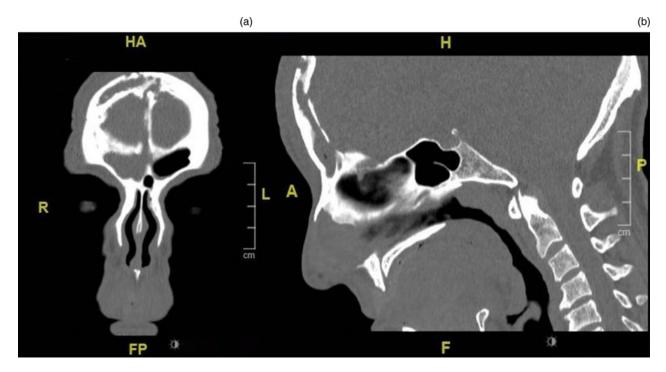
(a) Coronal and (b) sagittal computed tomography scans of the paranasal sinus, showing extensive chronic infective changes originating in the right frontal sinus, with destruction of the inner and outer tables of the vault, and associated soft tissue swelling in the frontal scalp tissues. Appearances are reminiscent of Pott's puffy tumour, but in a more chronic state. HA = head/anterior; H = head; R = right; L = left; A = anterior; P = posterior; FP = feet/posterior; F = feet
